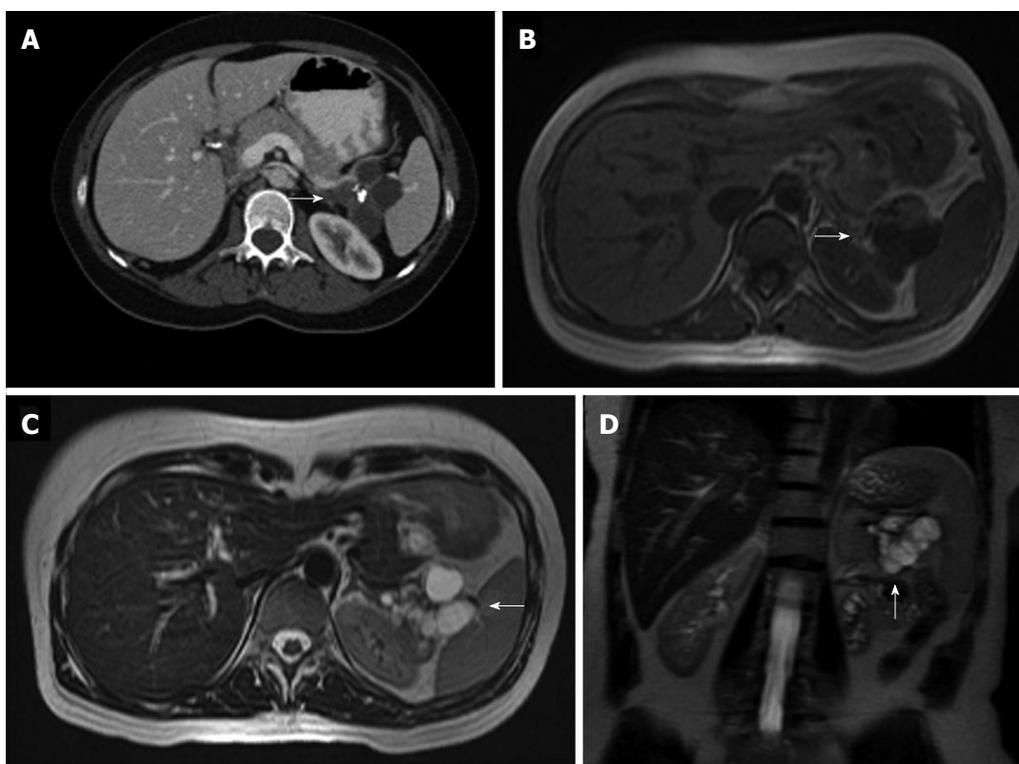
Axial nonenhanced multidetector computed tomography image. A: A polylobulated cystic lesion with a coarse calcification in its center (arrow), which is the pathognomonic central scar for serous cystadenoma; B-D: Magnetic resonance imaging show a cluster of small cysts (arrows), which are hypointense in T1-weighted images (B) and hyperintense in T2-weighted images (C, D), without visible communication within the cyst or the pancreatic duct. A central signal void is also identifiable.
